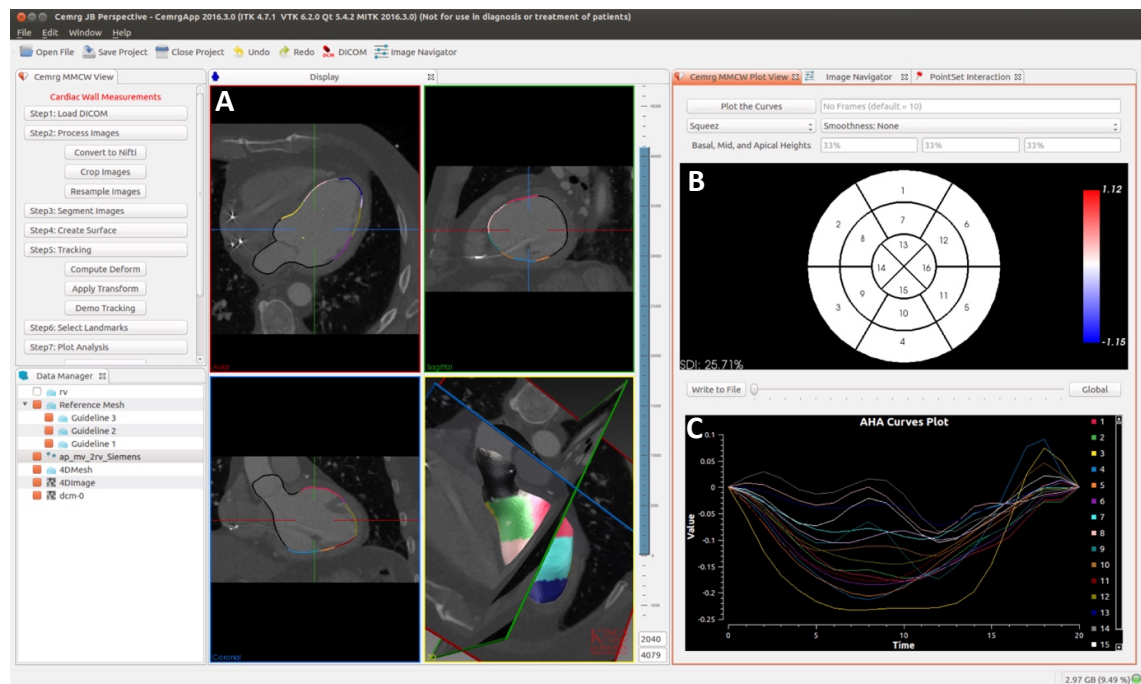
Cardiac CT dyssynchrony analysis
